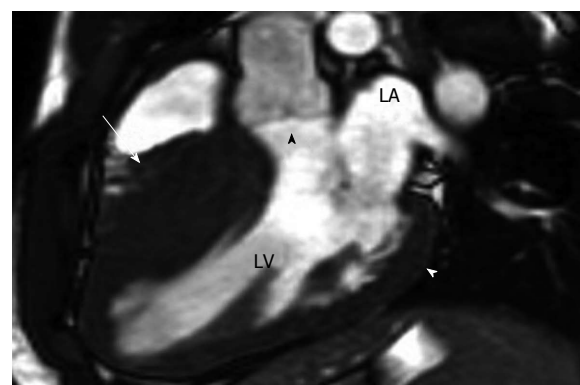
Hypertrophic cardiomyopathy^[105]. A: 2D SSFP cardiac magnetic resonance imaging, obtained in end diastole in the long-axis plane of the LV outflow tract (LVOT) in a 17-year-old boy with Hypertrophic cardiomyopathy found at family screening, shows marked asymmetric septal hypertrophy with a ratio of ventricular septal thickness (27 mm, arrow) to inferolateral wall thickness (9 mm, white arrowhead) of 3:1. Note that the hypertrophied septum encroaches on the LV lumen, causing mild narrowing of the LVOT (black arrowhead). LA: Left atrium; LV: Left ventricle.
